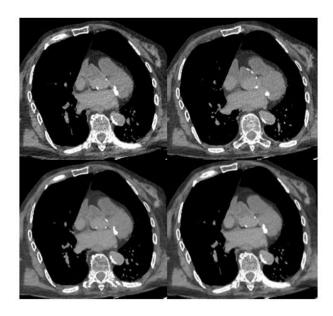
Comparison of images of the mediastinum with fusion CT and acquisitions at different energies: Respectively 80 KV (top left), 100 KV (top right), 120 KV (bottom left) and fusion CT reconstruction of the previous (bottom right).
